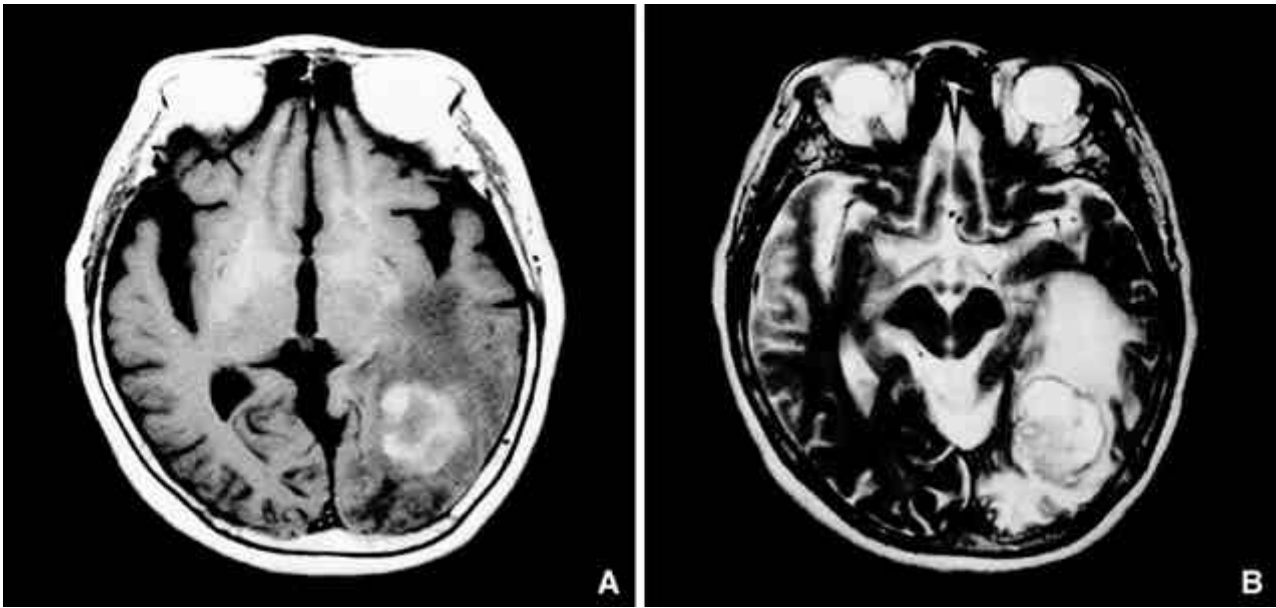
A: While the inferior-peripheral portion of the mass shows slightly high-signal intensity, the central portion shows low-signal intensity on T1-weighted images. B: While the inferior-peripheral portion of the mass shows iso-signal intensity, the central portion shows high-signal intensity on T2-weighted images.
